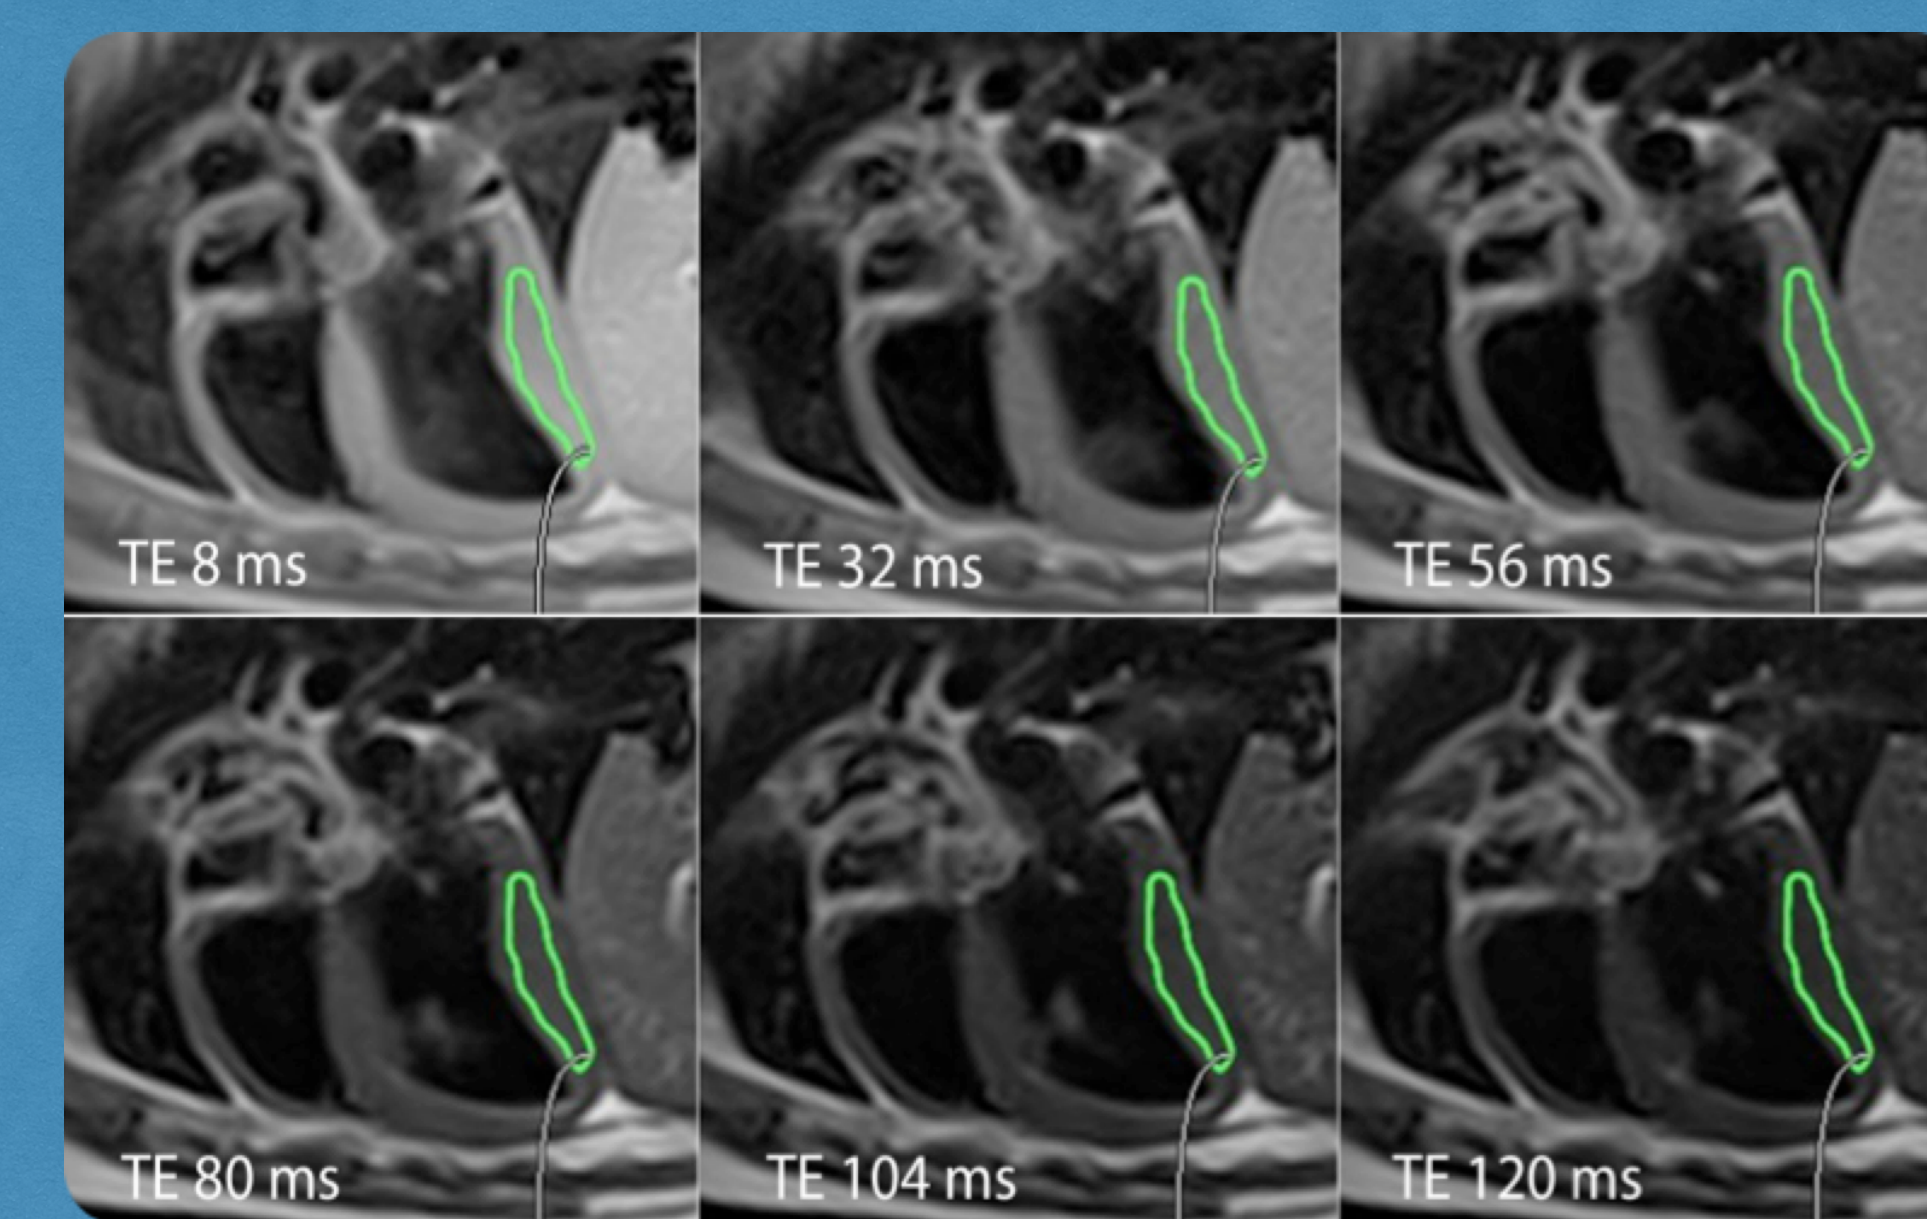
Parasagittal MRI images of the heart with a region of interest drawn to include the left ventricular free wall used to calculate T2 relaxation time.
